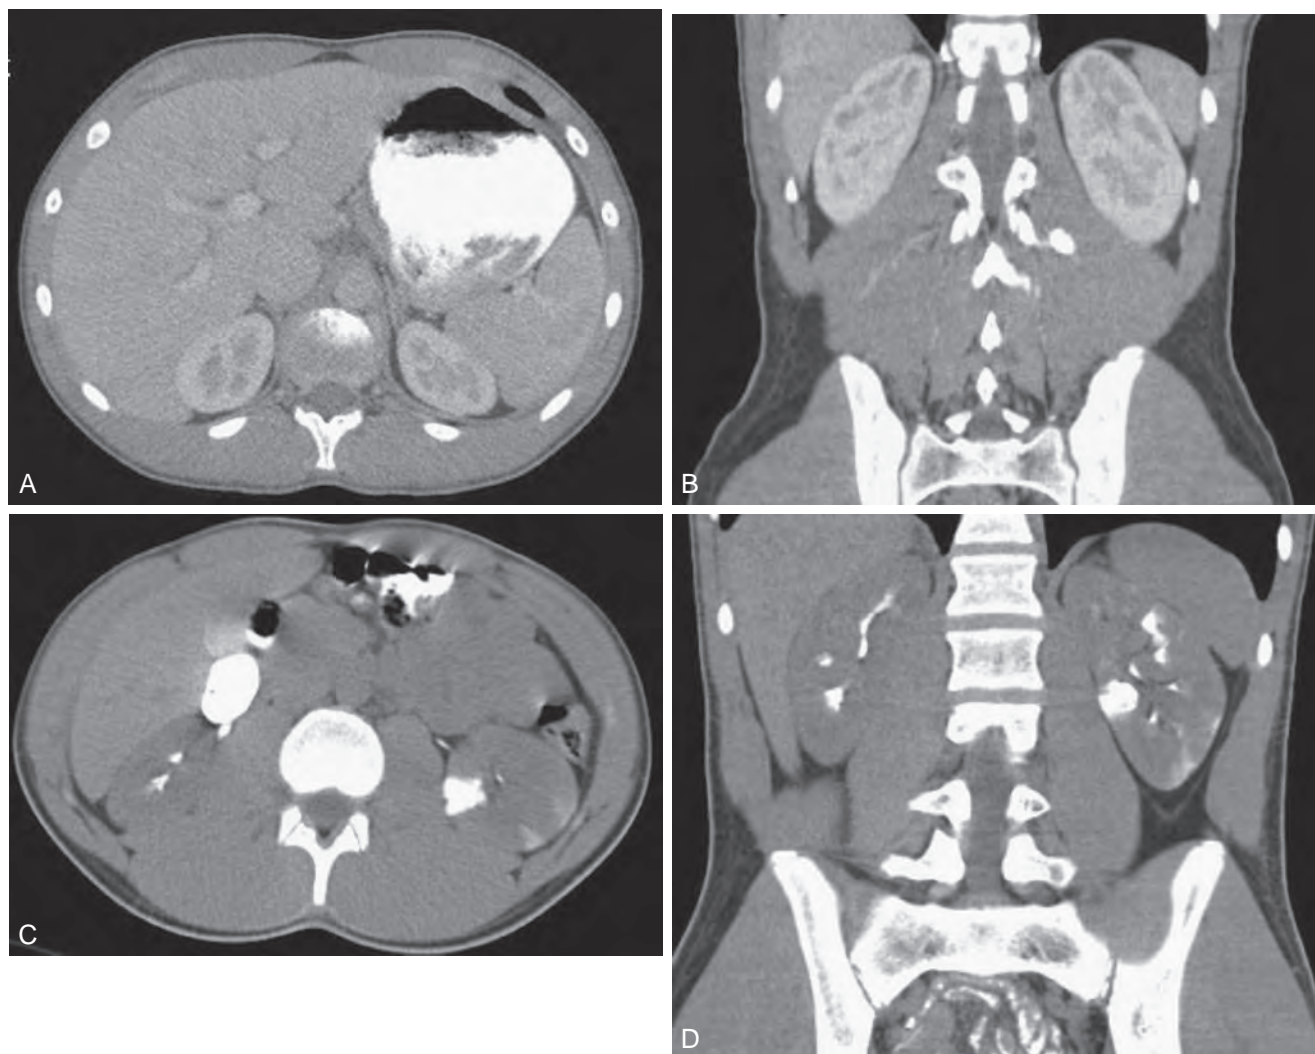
Computed tomography (CT) images, acute and delayed, with grade 1 renal trauma. A, Acute CT image of grade 1 renal trauma. Note normal-appearing parenchyma. B, Acute CT image coronal reconstruction of grade 1 renal trauma. C, Two-hour delayed CT image of grade 1 renal trauma revealing renal contusion with delayed excretion of contrast in cortex of contused renal parenchyma. D, Two-hour delayed coronal reconstruction of CT grade 1 renal trauma revealing delayed excretion of contrast in cortex of contused renal parenchyma.
